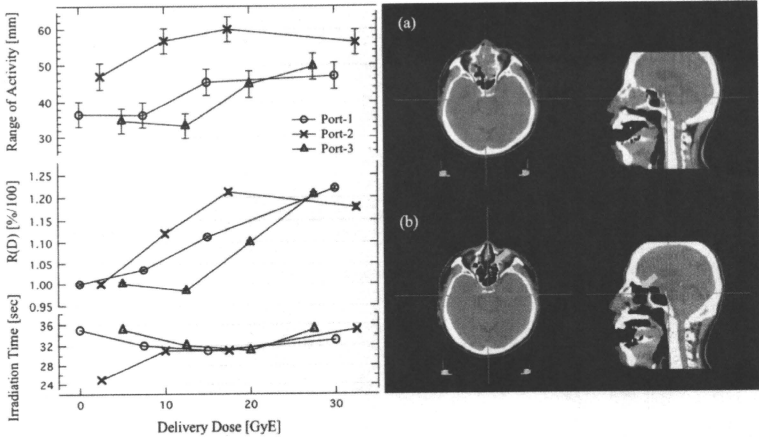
Changes in the values of the activity range and proton beam irradiation time per fraction dose at each irradiation field of Port-1, Port-2, and Port-3. Axial and sagittal CT images of the head and neck before treatment (a) and after delivery doses of 35 GyE (b).
